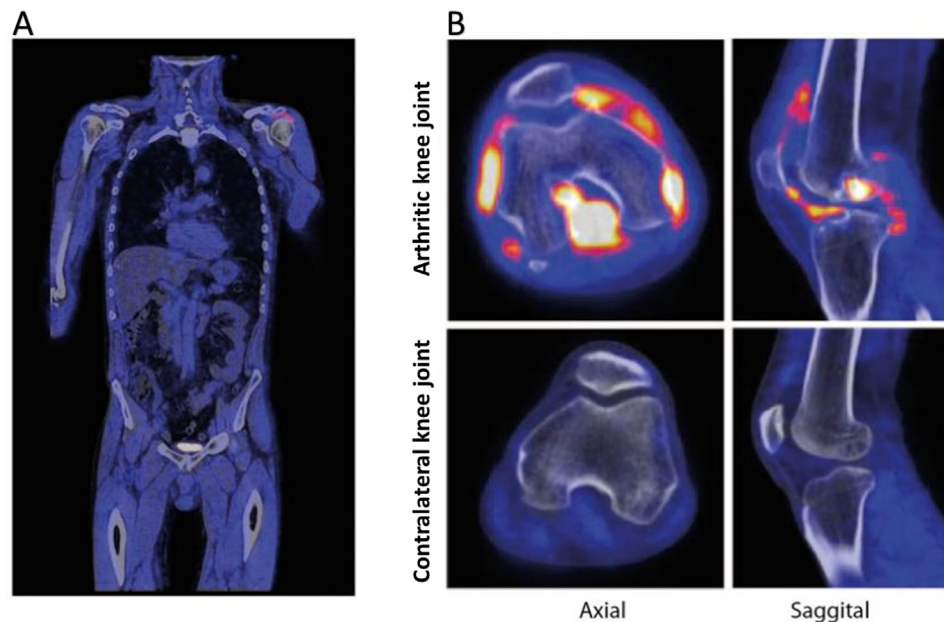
FAPI PET/CT findings in a patient with rheumatoid arthritis. FAPI PET/CT with FAPI-04 tracer accumulation in left arthritic shoulder (A) and synovium of arthritic knee (B) in patient with rheumatoid arthritis. Originally published by Dorst, D.N., et al.,⁶⁹ *Targeting of fibroblast activation protein in rheumatoid arthritis patients: imaging and ex vivo photodynamic therapy*. Rheumatology (Oxford), 2021 <https://doi.org/10.1093/rheumatology/keab664> licensed under Creative Commons Attribution-NonCommercial (<https://creativecommons.org/licenses/by-nc/4.0/>).
